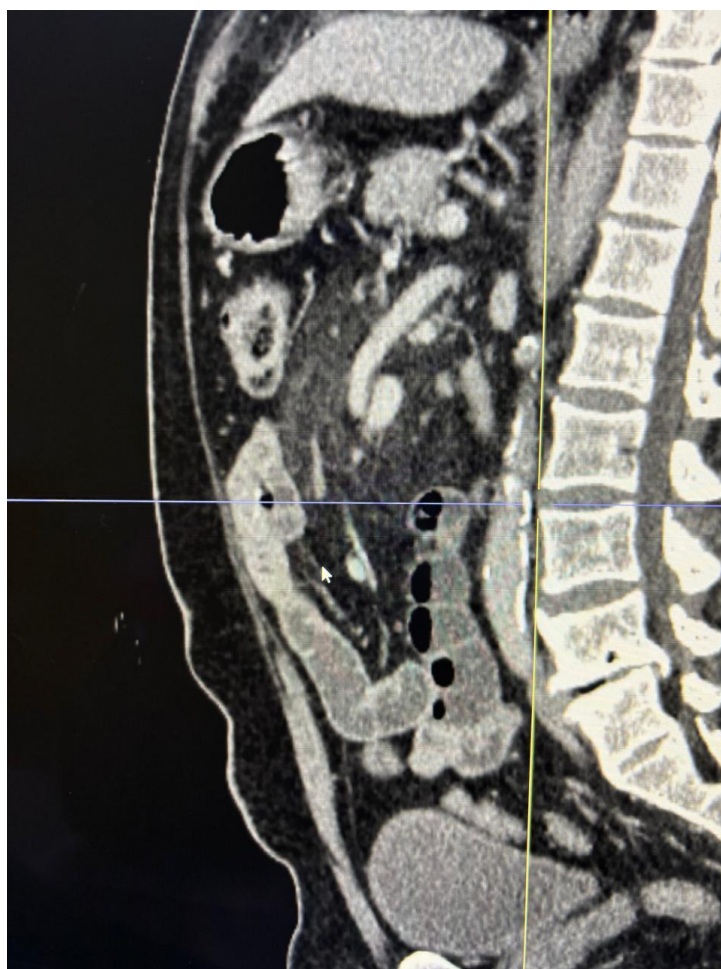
Figure D - Sagittal CT scan
